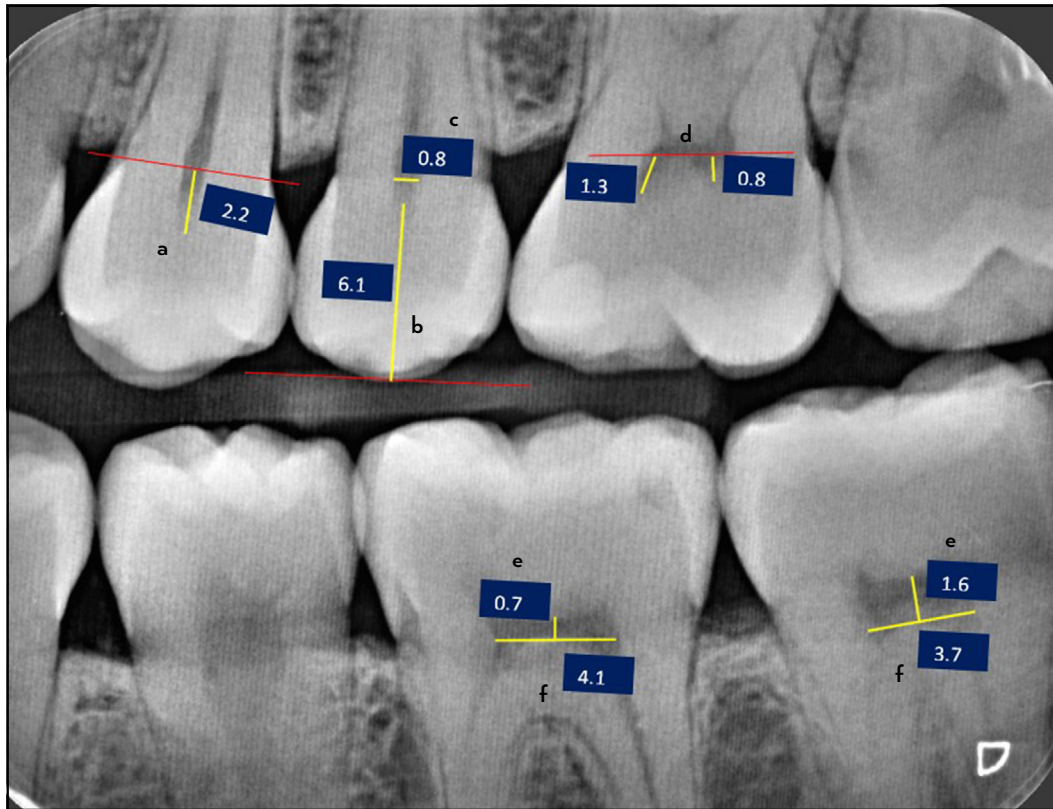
Morphological measurements (in millimetres) related to the pulp chamber using a 2D bitewing radiographic image – (a) Distance between the level of CEJ to highest pulp horn. (b) Distance from occlusal plane to pulp horn area. (c) Mesio-distal width of the pulp chamber at CEJ of a single-rooted tooth. (d) Distance from lowest level of the pulp roof to the highest point of the pulp horns. (e) Distance from highest point of pulp chamber floor to the lowest point of the pulp roof. (f) Mesio-distal width of the pulp chamber at level of the highest point of the pulp chamber floor in mandibular molars
